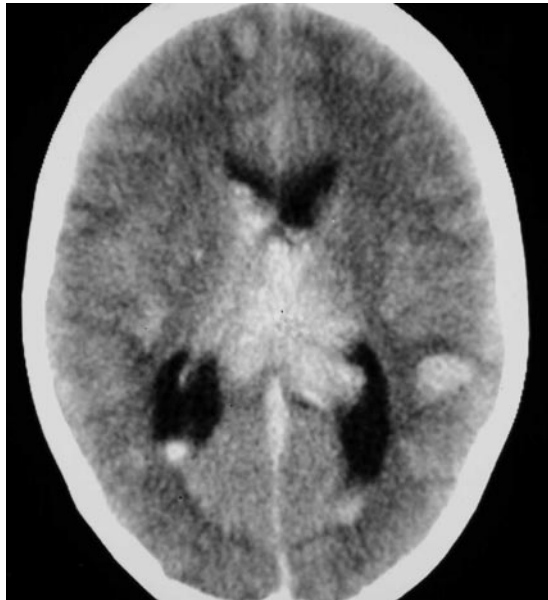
Leukemic debut with fulminant leukocytosis in an 8-year-old boy who presented with a sudden headache, progressive lethargy, and coma. Enlargement of the spleen was detected at physical examination; hyperleukocytosis (white blood cell count of $800,000/\text{mm}^3$) and thrombocytopenia (platelet count of $58,000/\text{mm}^3$) were significant laboratory parameters. ALL of the L1T type with cerebrospinal fluid involvement was diagnosed. Axial computed tomographic (CT) scan shows multiple hemorrhagic lesions involving the corpus callosum and cerebral white matter with intraventricular extension. The lesions did not enhance after administration of contrast medium. Chemotherapy was started, but the patient died in 48 hours.
